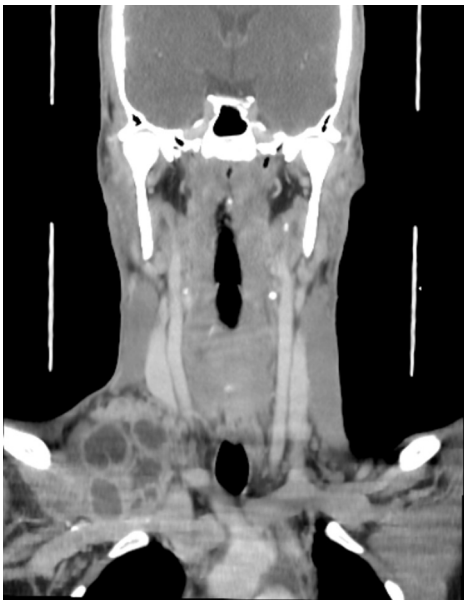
CT scan from a 22-year-old patient with HS after 2 months of antituberculosis treatment. CT image of the neck shows right level VI and bilateral level V lymphadenopathy, the largest confluent with a hypodense center, suggesting necrotic degeneration at the right supraclavicular fossa.
